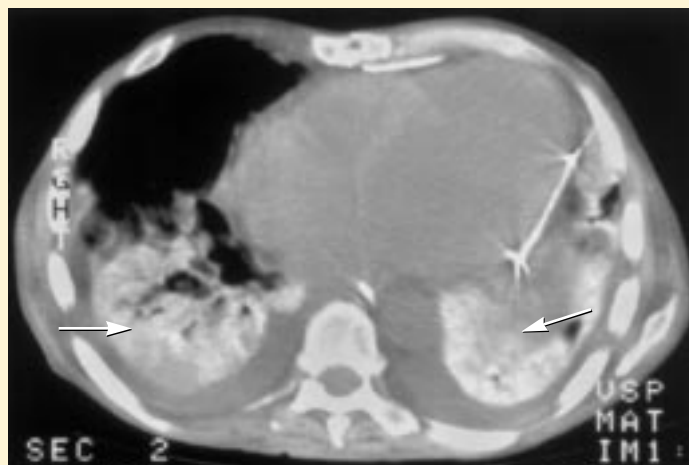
A computed tomographic scan without contrast in a patient receiving amiodarone reveals infiltrates in both lung bases (arrows), due to the iodine content in amiodarone. This enhancement, however, is not pathognomonic for amiodarone toxicity.
